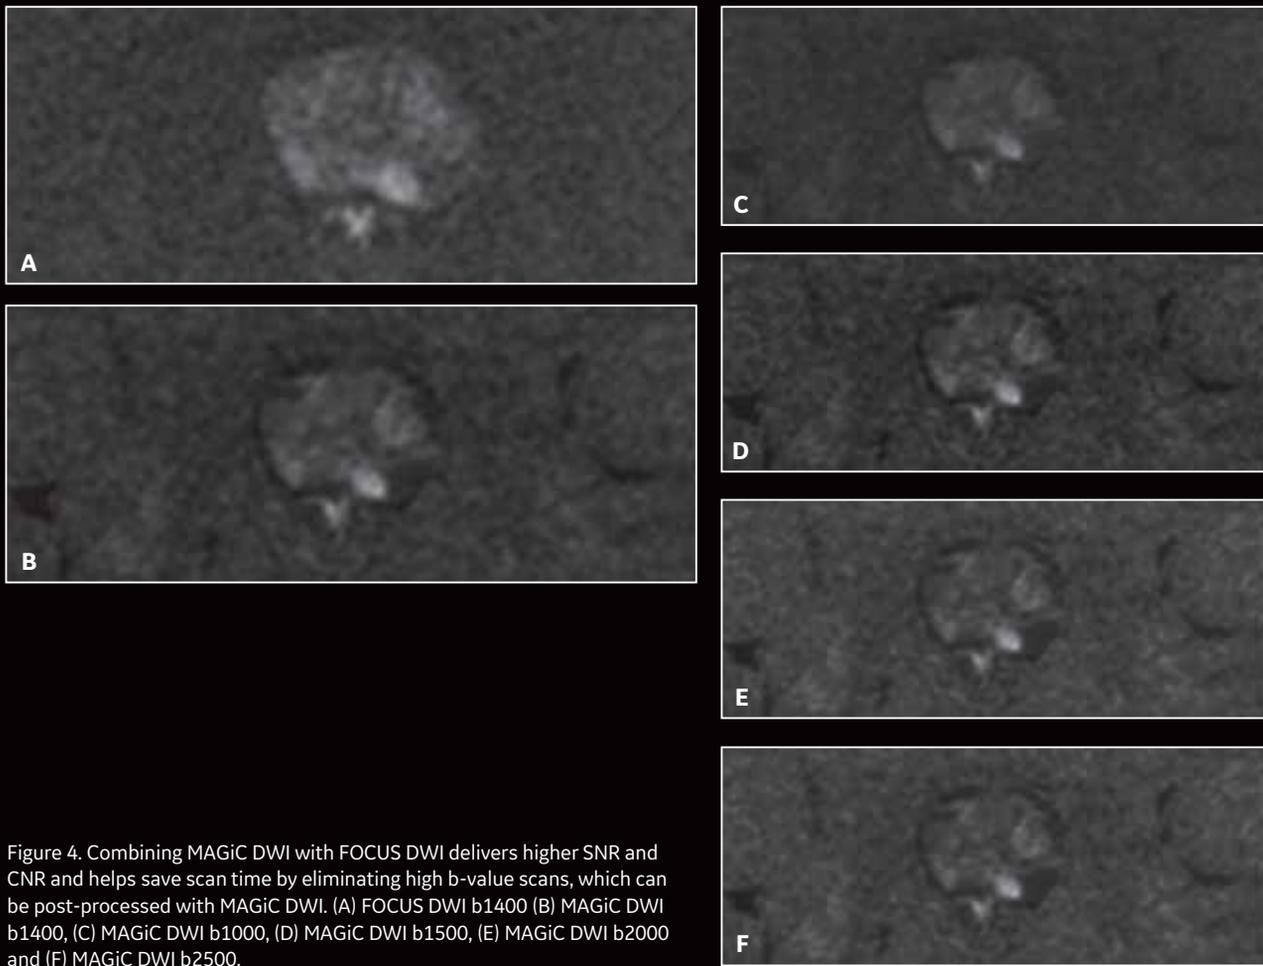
Combining MAGiC DWI with FOCUS DWI delivers higher SNR and CNR and helps save scan time by eliminating high b-value scans, which can be post-processed with MAGiC DWI. (A) FOCUS DWI b1400 (B) MAGiC DWI b1400, (C) MAGiC DWI b1000, (D) MAGiC DWI b1500, (E) MAGiC DWI b2000 and (F) MAGiC DWI b2500.
